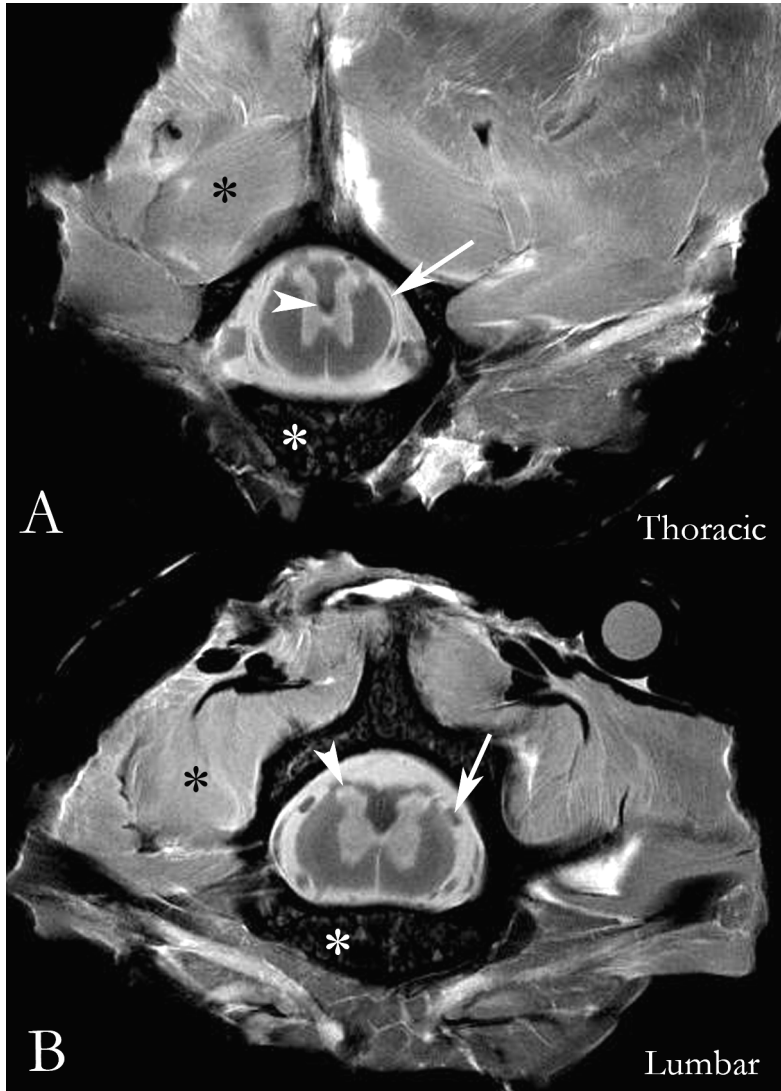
High Resolution PD weighted MRI of the spinal cord-spine block (NA=32); A: thoracic, B: lumbar. White asterisk: bony spine (vertebra). Black asterisk: paravertebral muscle. Arrowhead in A: corticospinal tract. Arrow in A: dural sac. Arrowhead in B: substantia gelatinosa. Arrow in B: nerve root.
